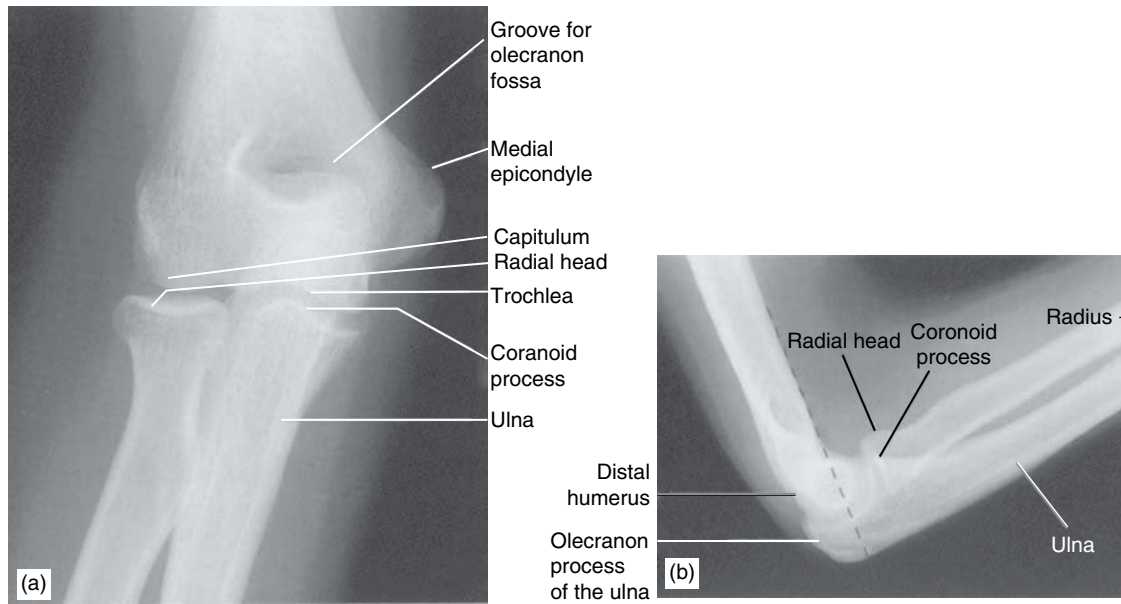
(a) Anteroposterior and (b) lateral radiographs of the elbow. Reproduced from Butler P, Mitchell AWM, Ellis H, *Applied Radiological Anatomy*, Cambridge University Press, Cambridge, 1997.
